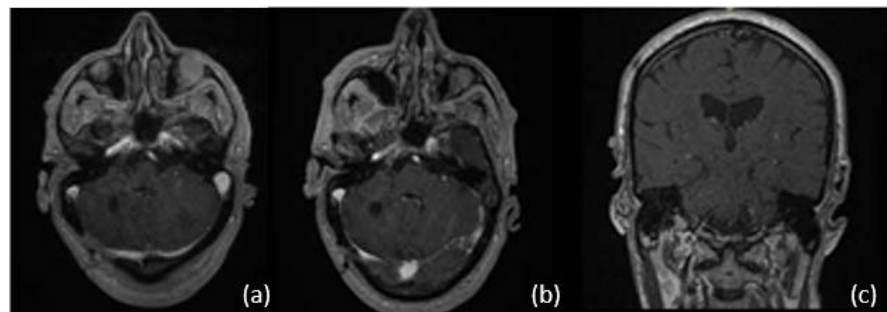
Postoperative axial T1-weighted postcontrast (a) (b), postcontrast sagittal T1-weighted (b) postcontrast T1-weighted coronal (c) confirmed complete excision of the tumor.
